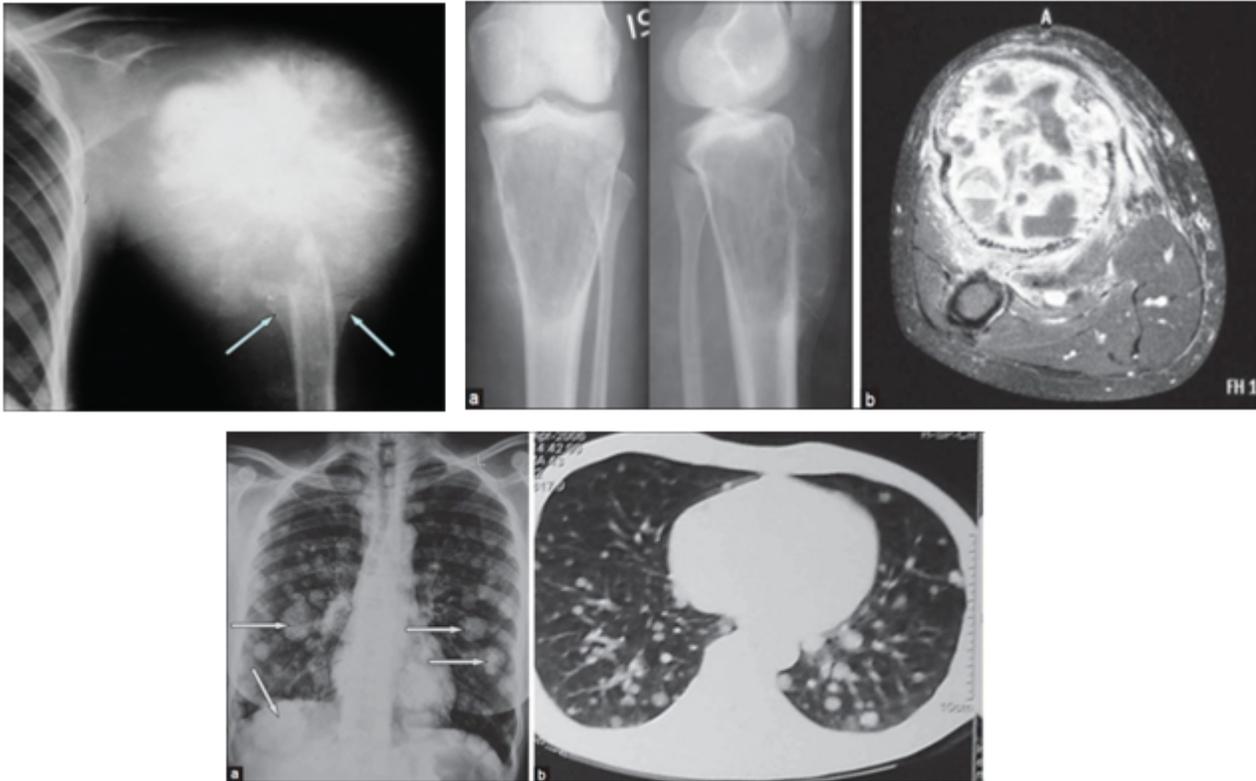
X-ray of humerus anteroposterior view showing osteosarcoma of the proximal humerus- typical sun burst or sun ray appearance, new bone formation in soft tissues, and Codman's triangles (arrows)
